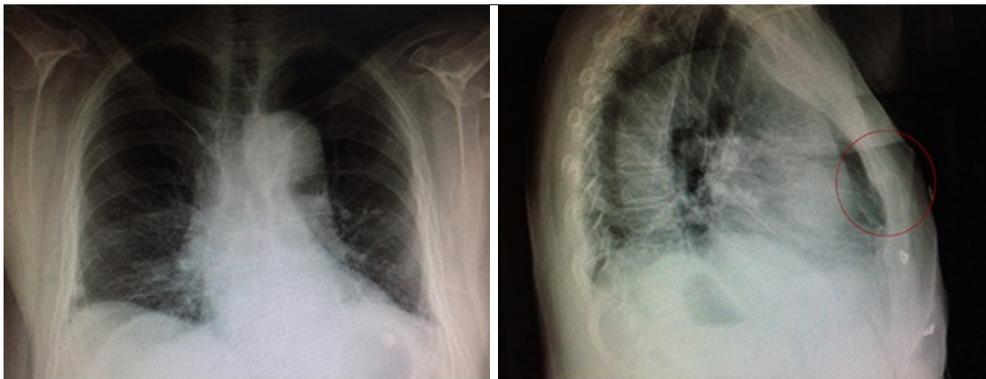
Posteroanterior (left), and lateral (right) chest X-rays of the patient. Fracture line is marked with red circle.
